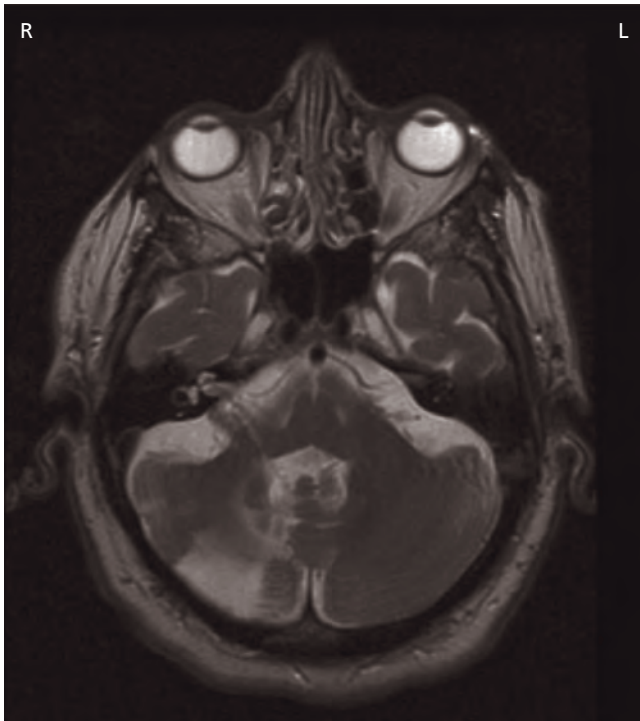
Brainstem and cerebellar infarction (MRI T2W).
